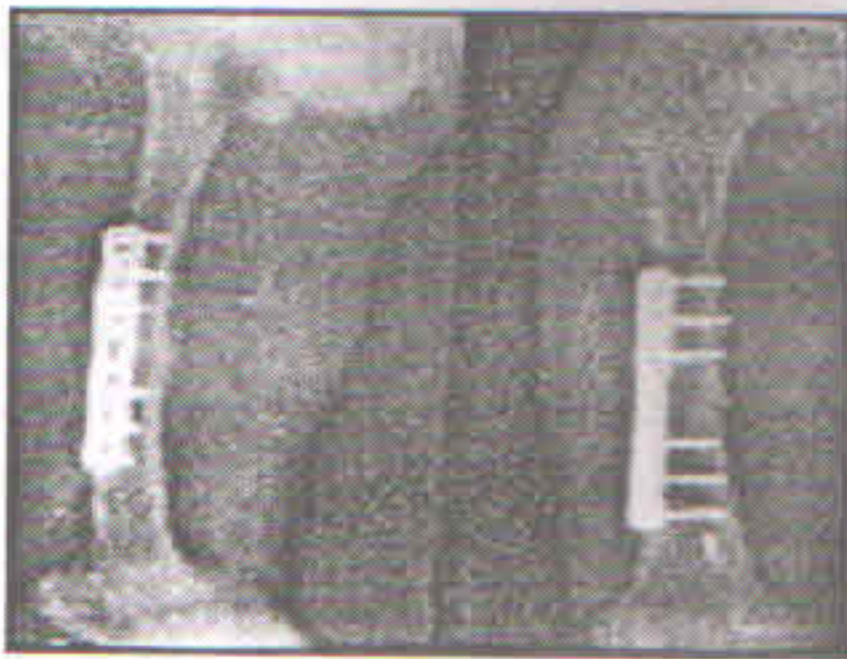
Followup x-ray of 3 months
